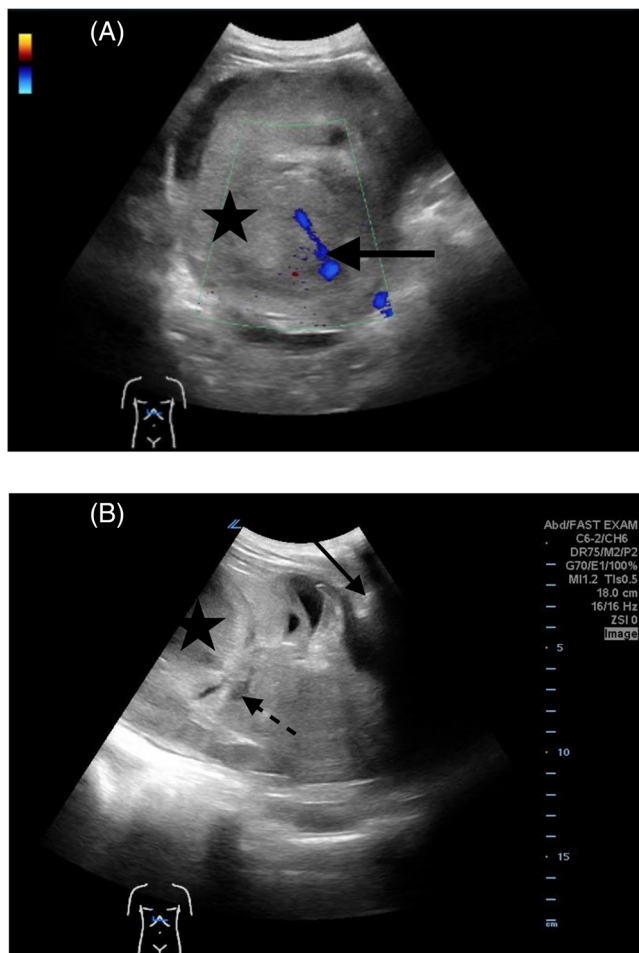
(A) POCUS showing turbulent Doppler flow within the bladder indicating active bleeding. (B) Clot at various stages within the distended bladder with mixed echogenicities.
